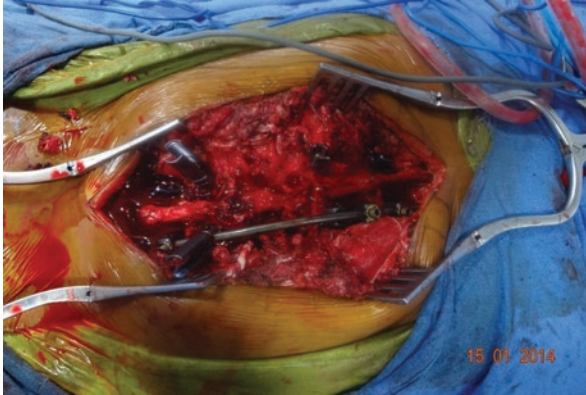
Intraoperative radiograph of the above patient with temporary rod on one side and excised pedicle on the other side
